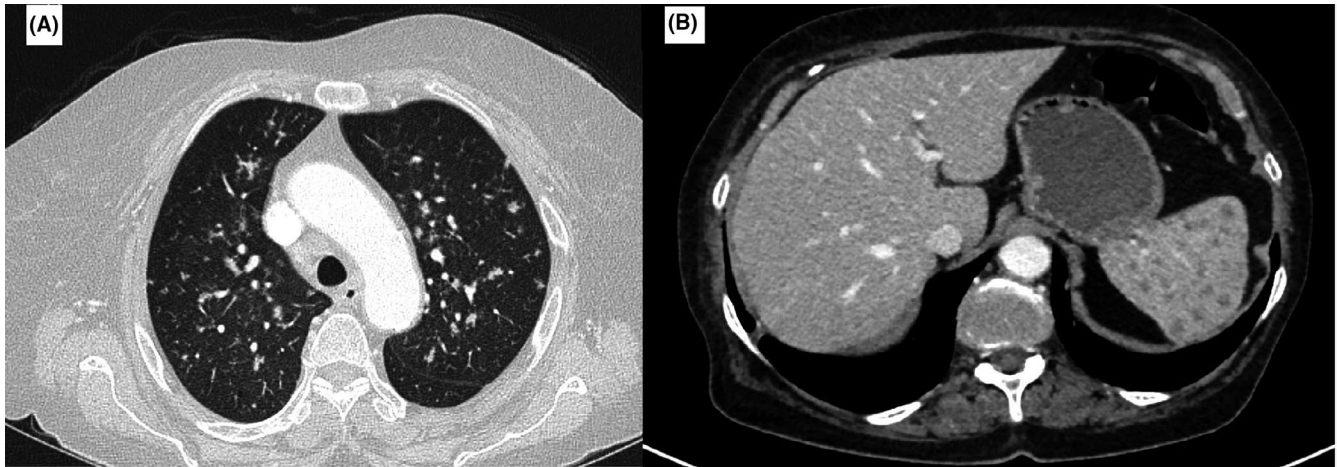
CT scan of the patient. A, pulmonary parenchymal window, showing diffuse involvement of the two pulmonary fields, made of micronodules in places achieving the appearance of rosette nodules. B, abdominal CT scan in parenchymal window, showing a multinodular aspect of the spleen
